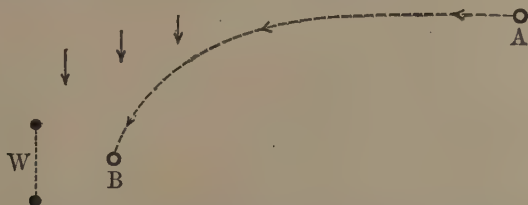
DISCRIMINATIVE REACTING TO THE SLOPING ASPECT OF THE GROUND BY A CHILD PLAYING CROQUET
